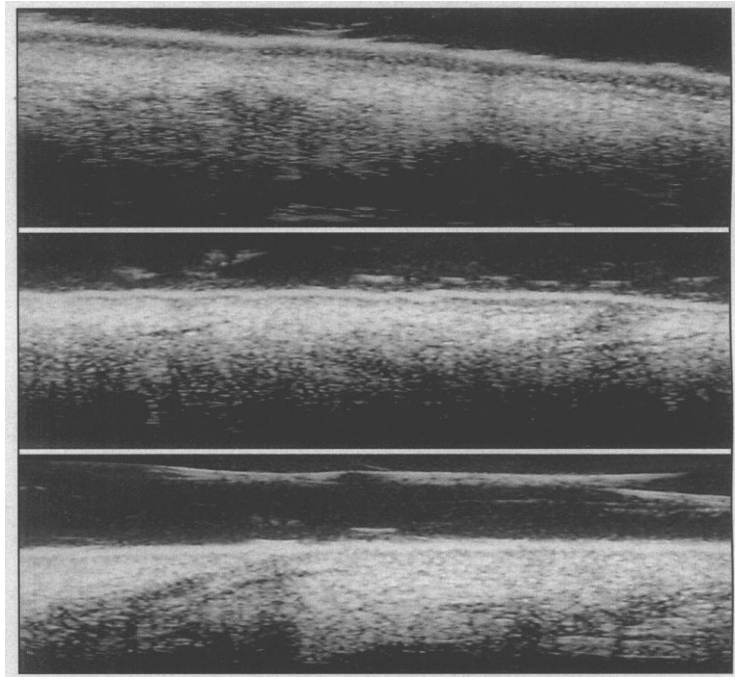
Top, Ultrasound image of a psoriatic plaque before treatment. Note the thickness of band B. Center, Ultrasound image when there has been moderate, but not complete, clinical improvement of the psoriasis Band B is still visible, although of decreased width compared with width before therapy. Bottom, Ultrasound image of a nearby clinically uninvolved area of skin. One small division on the scale equals 100 p.m. (Hoffmann et al., 2001).
